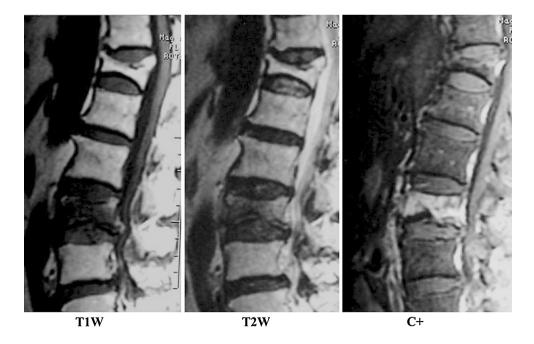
Acute vertebral fracture was confirmed by MRI with low signal intensity on T1-weighted imaging (T1W), enhanced signal intensity on T2-weighted imaging (T2W), and contrast enhancement (C+)
